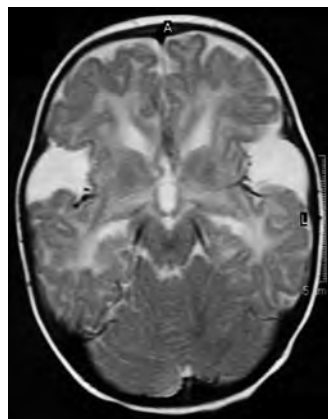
13-month-old girl with glutaric aciduria type I. MRI of the head, T2-sequences: symmetrical enlargement of frontotemporal CSF spaces, large sylvian fissures and hyperintensity of the white matter and subcortex.
